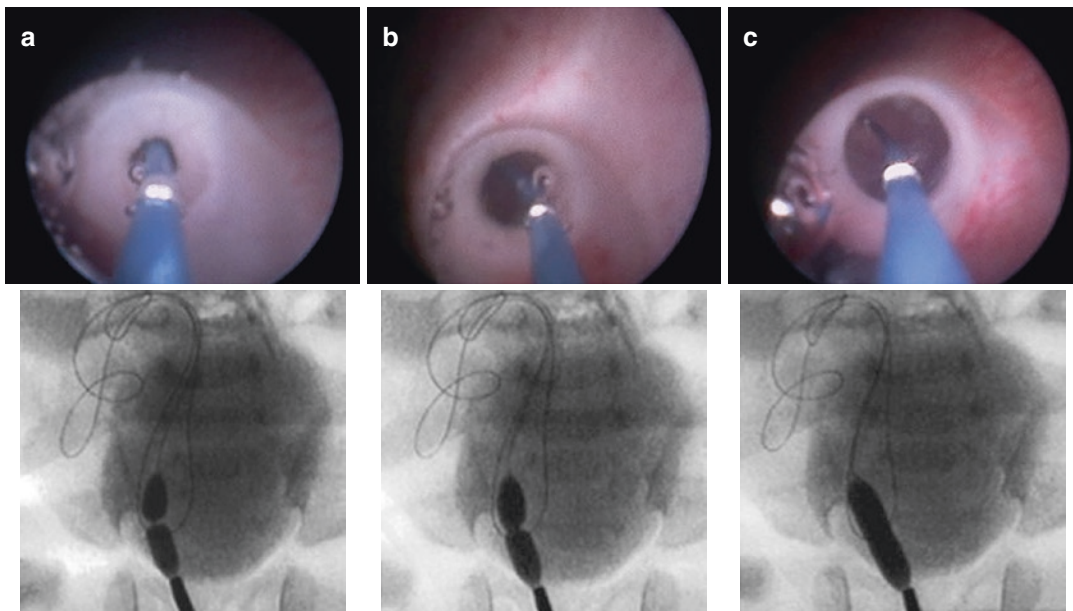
Balloon inserted through right VUJ, endoscopic view and radiographic control. (a) Initial balloon inflation with the presence of stenotic ring; (b) progressive
